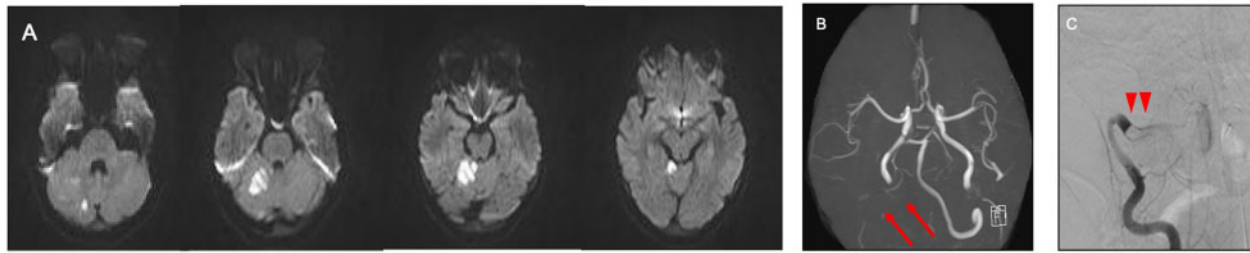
(A) Diffusion-weighted magnetic resonance image showing cerebral infarction in right cerebellar hemisphere. (B) Magnetic resonance angiography showing the absence of the right vertebral artery (red arrow). (C) Cerebral angiography showing a right vertebral artery occlusion with thrombus (red arrowhead).
